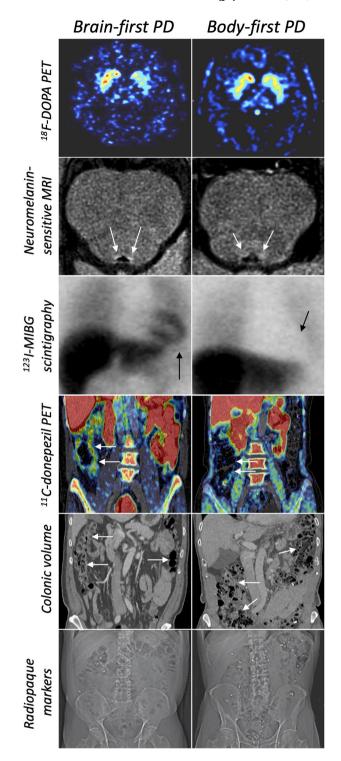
Representative images of brain-first (left column) and body-first PD patients (right column). Brain-first PD patients display asymmetric striatal ¹⁸F-FDOPA loss – body-first PD patients a more symmetric loss. Body-first PD patients display lower locus coeruleus signal on neuromelanin-sensitive MRI, lower cardiac ¹²³I-MIBG signal, and lower colonic ¹¹C-donepezil PET signal than brain-first PD patients (arrows). Larger colon volume and more retained radiopaque markers are seen in body-first PD patients compared to brain-first PD patients – both measures of colonic dysfunction.
